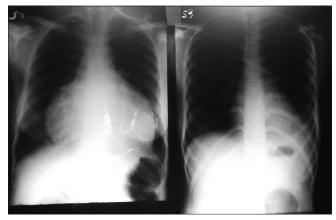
Chest X-ray prior to treatment and then after treatment
